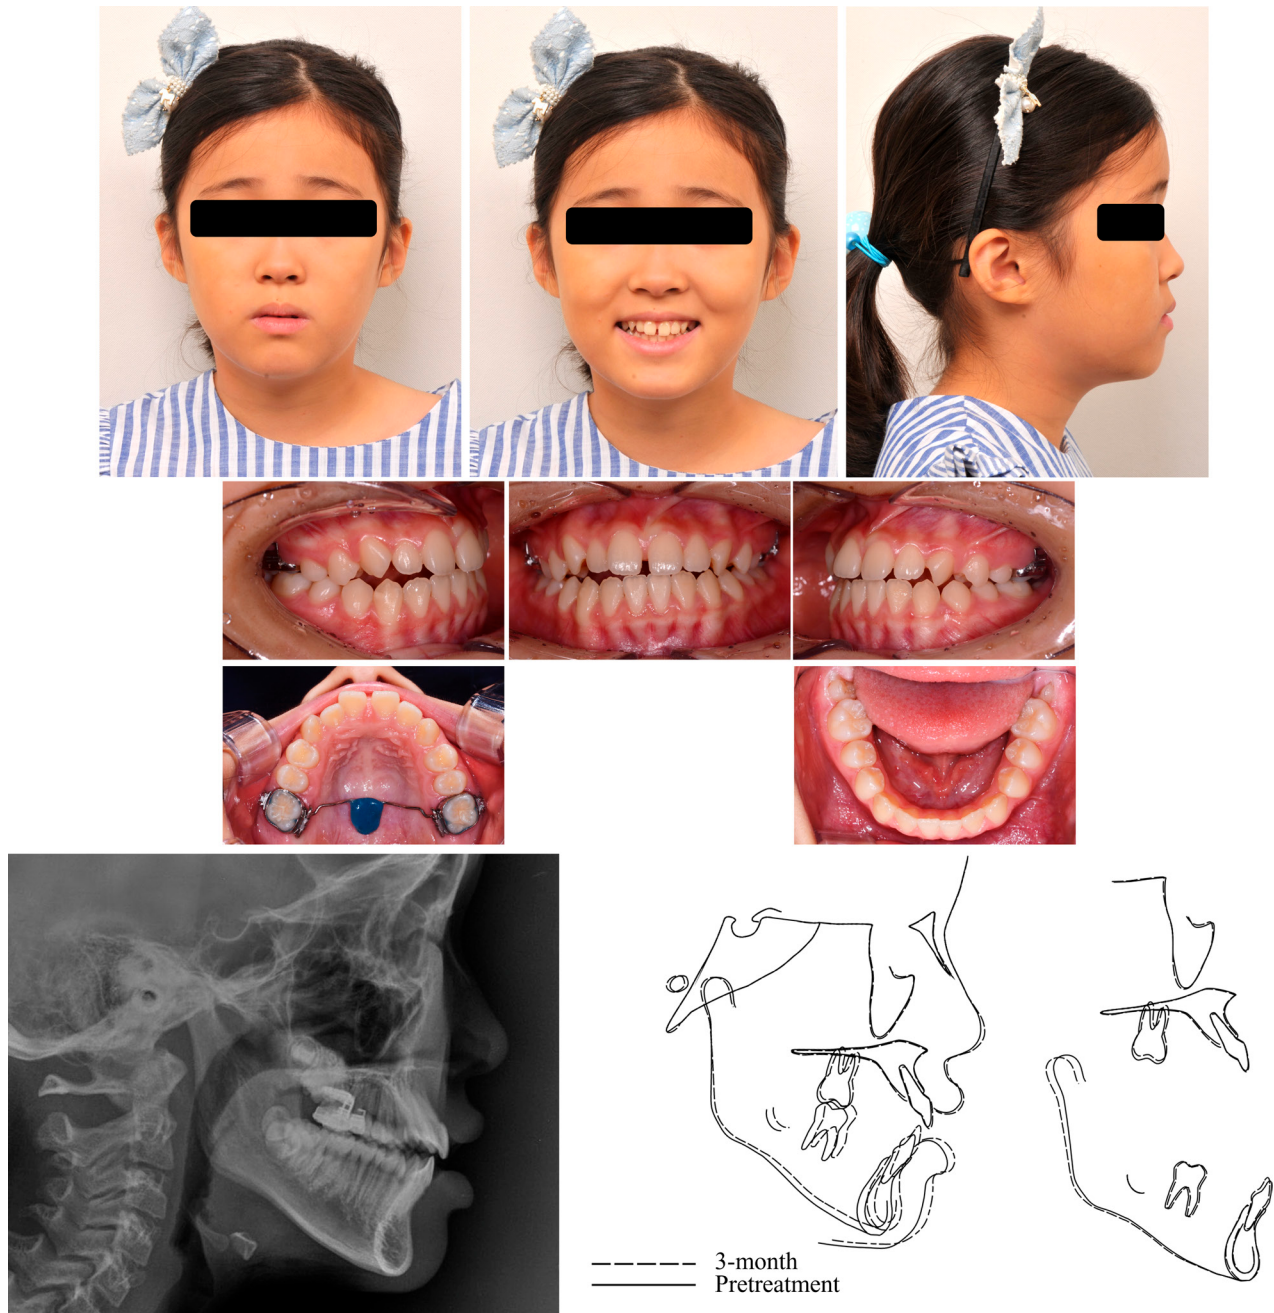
Records at 3 months of treatment, including extraoral and intraoral photographs, cephalogram, and superimposition of radiographs taken before treatment and after 3 months of treatment.
